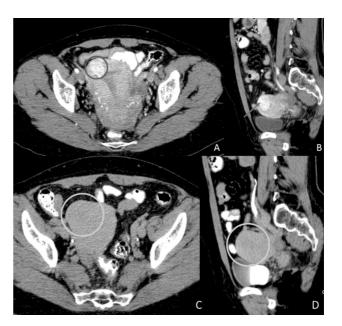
Contrast enhanced CT in the same patient performed to further evaluate and localize the mass noted on the saline sonohysterogram and hysteroscopy. On the axial CT image (5A), an enhancing mass in the right uterine fundus is seen (blue circle) measuring 169 HU (compared to the normal myometrium measured 107 HU). This mass can also be well visualized on the sagittal reformatted image (5B, blue arrow), spanning the entire thickness of the myometrium. The delayed images from the same CT scan performed 120 seconds after the initial CT scan are demonstrated in 5C and 5D. The mass is now indistinguishable from the background normal parenchyma (orange circles) on the axial and sagittal reformatted images (5A and 5B).
